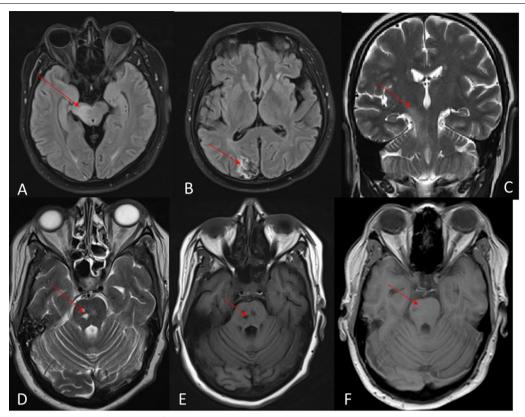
Magnetic resonance imaging (MRI) brain of patient 1 (A–C). A, B Fluid-attenuated Inversion Recovery (FLAIR) axial images showing hyperintense lesion in midbrain and gliosis in right occipital area (red arrows); C coronal *T*2 image showing cascade sign (red arrow). MRI of patient 3 (D–F), (D, E) axial *T*2 and *T*1 image showing pontine base discrete hyperintense and hypointense lesion (red arrow); F axial *T*1 image showing decrease in lesion with treatment
